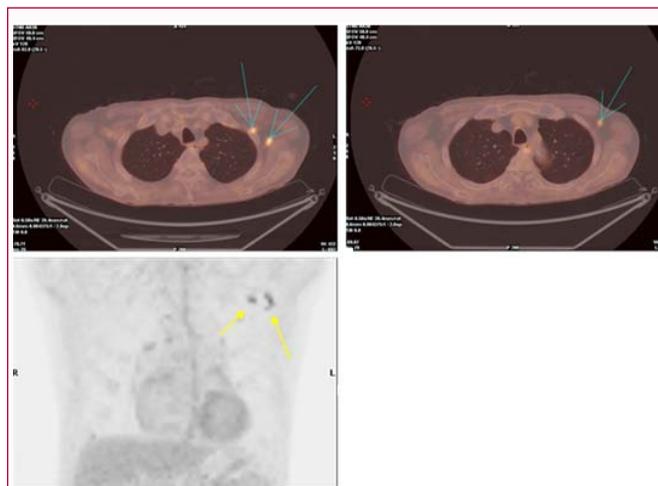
70 year old female FDG PET/CT scan cross section view (blue arrow), and coronal view (yellow arrow) showing hypermetabolic uptake in the left axillary level I-III lymph nodes.
